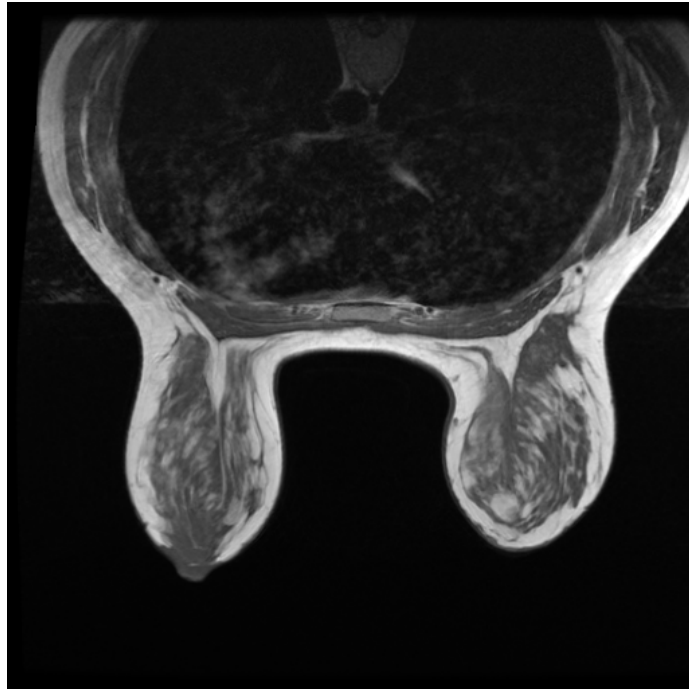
Typical axial image from a T1-weighted breast MRI volume
